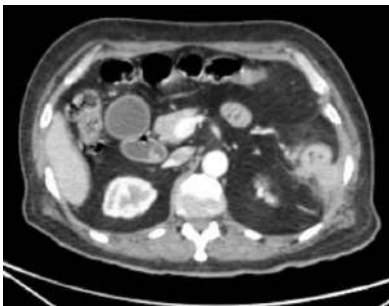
CT showing locally advanced splenic flexure adenoca with peritoneal involvement
